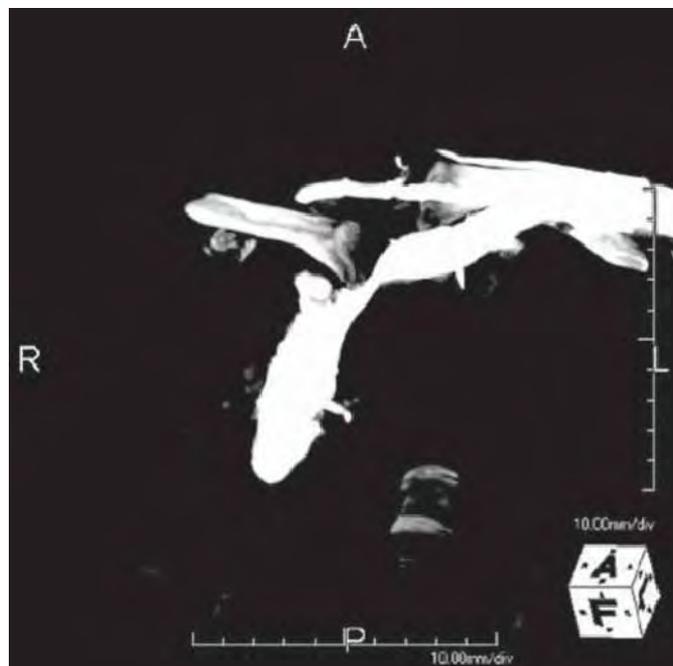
CT reconstruction demonstrates retrosternal dislocation of clavicle compressing the brachiocephalic vein.
